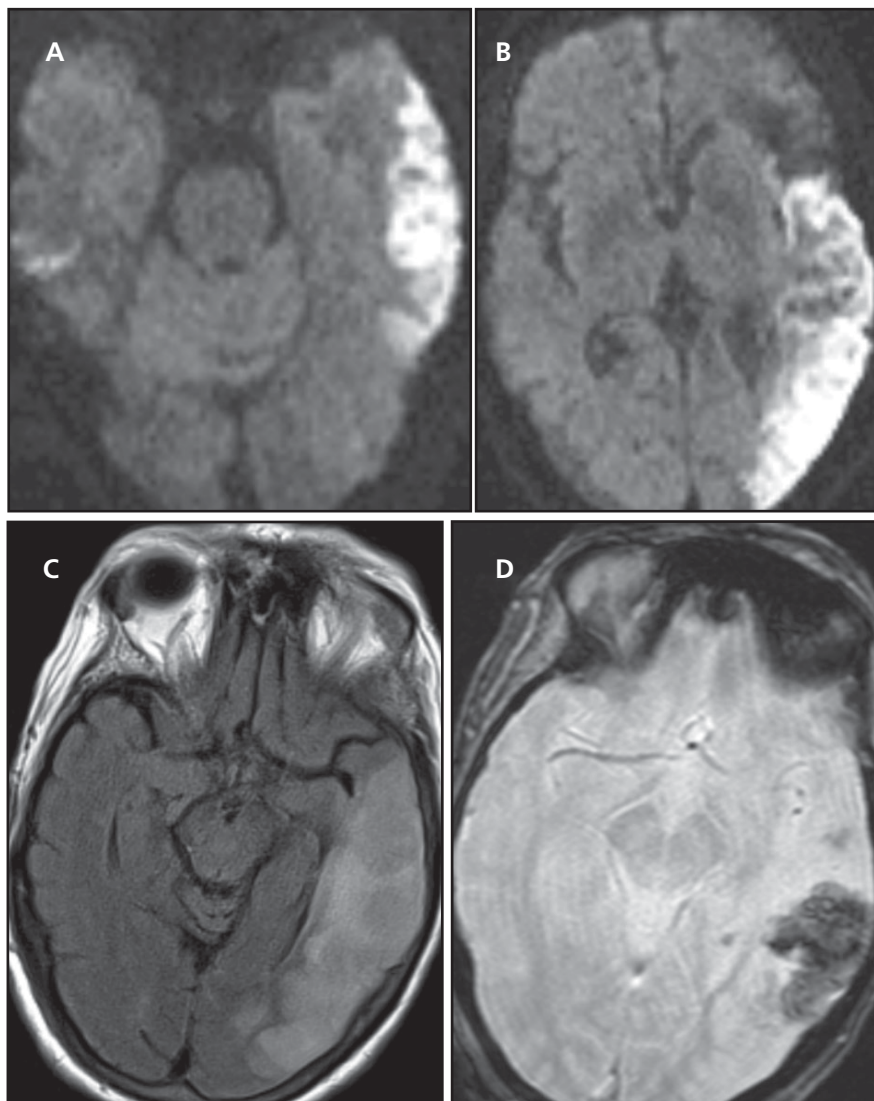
Early subacute left MCA infarct. Axial diffusion weighted images (A and B) show restricted diffusion corresponding to the territory of the left inferior MCA division (ADC not shown). Axial FLAIR image (C) reveals associated gyral edema with loss of normal gray-white interface. Axial GRE image (D) demonstrates susceptibility artifact due to complicating hemorrhagic transformation.
